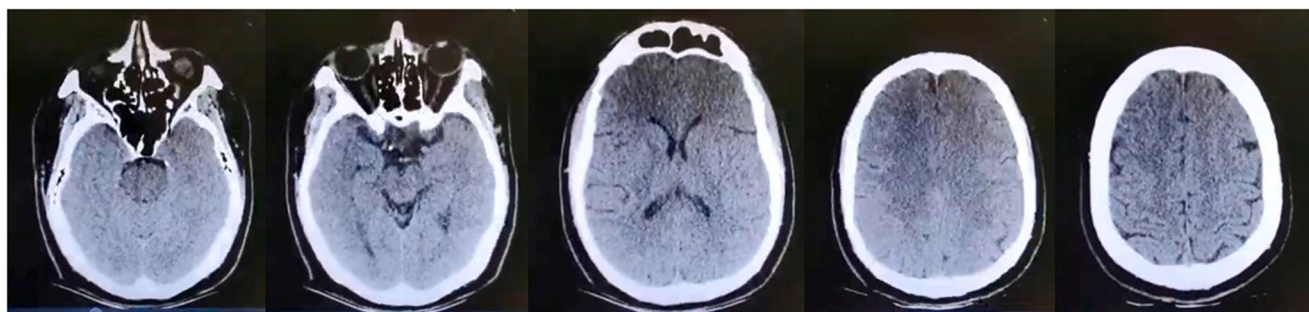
The image showed a series of axial slices from a non-contrast cranial computed tomography scan. The analysis of the brain structures revealed symmetry and preservation of the sulci, gyri, and cerebral ventricles, with no signs of mass effect, midline shift, or hypodense areas suggestive of acute ischemic injury. There were no intracranial hemorrhages, abnormal collections, or apparent structural alterations that could explain the clinical presentation of persistent convergent strabismus and diplopia.
